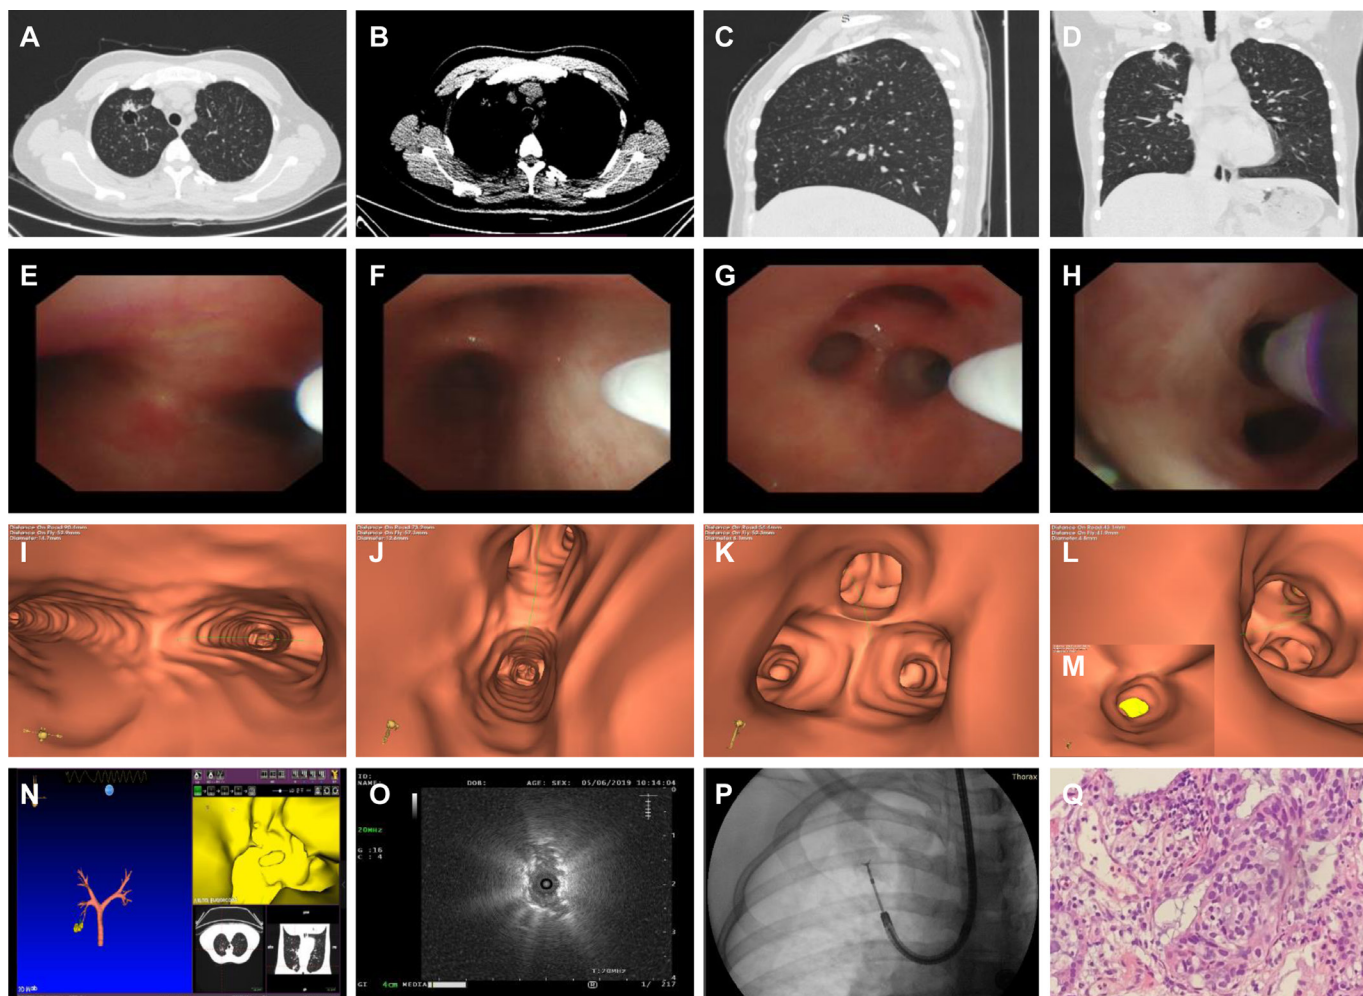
A representative case of ENB in combination with rEBUS and a GS using a thin bronchoscope with fluoroscopy for the diagnosis of a PPN. (A–D) CT scan of the chest showed a PPN in the right upper lobe with a long diameter of 16.6 mm in the axial plane. (E–H) White light bronchoscopy images. (I–L) Corresponding ENB images. (M) Target bronchus leading to the nodule (yellow) as shown by the ENB system. (N) The panel of the ENB system when the locatable wire reached the nodule (yellow). (O) The rEBUS probe confirmed the nodule. (P) Biopsy under fluoroscopy. (Q) The pathological examination revealed adenocarcinoma (200× magnification). ENB, electromagnetic navigation bronchoscopy; GS, guide sheath; PPN, peripheral pulmonary nodule; rEBUS, radial endobronchial ultrasound.
